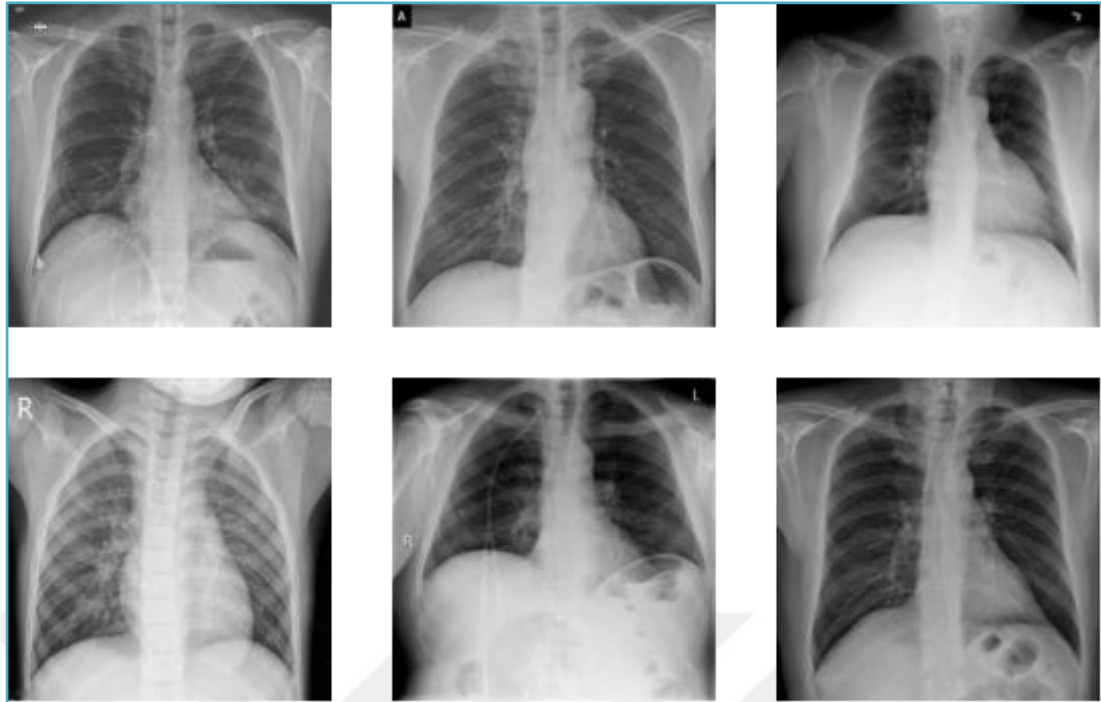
Chest Radiographs & Chest X-Rays & CXRs.
